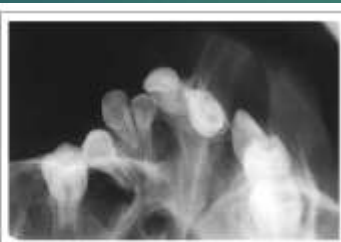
Case 1: Upper standard occlusal radiograph showing palatal fistula.
